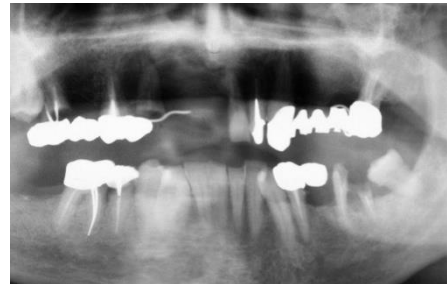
On the radiograph, the lesion is lightly radiopaque.*
